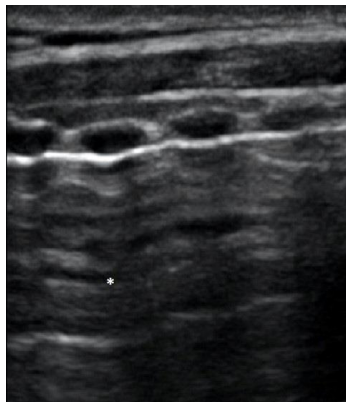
Long axis neck ultrasound from a healthy individual.
